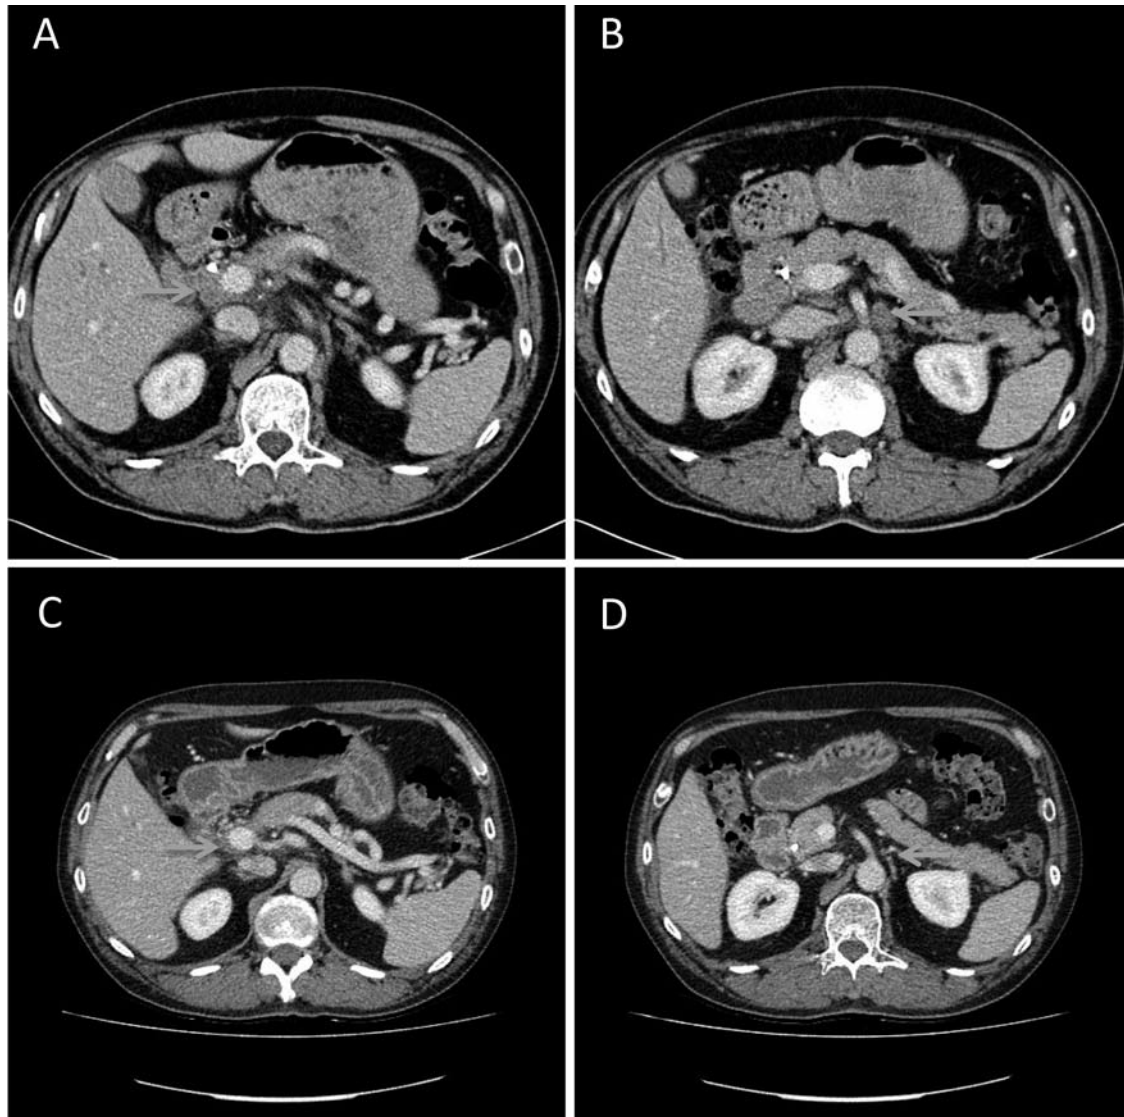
Computed tomographic (CT) scan showing a soft-tissue mass posterior to the common bile duct and adjacent to the portal vein (arrow in A) and enlarged retroperitoneal lymph nodes (arrow in B). Follow-up CT scan after polychemotherapy showing distinct decrease of the soft-tissue mass (arrow in C) and regression of the lymph nodes (arrow in D).
